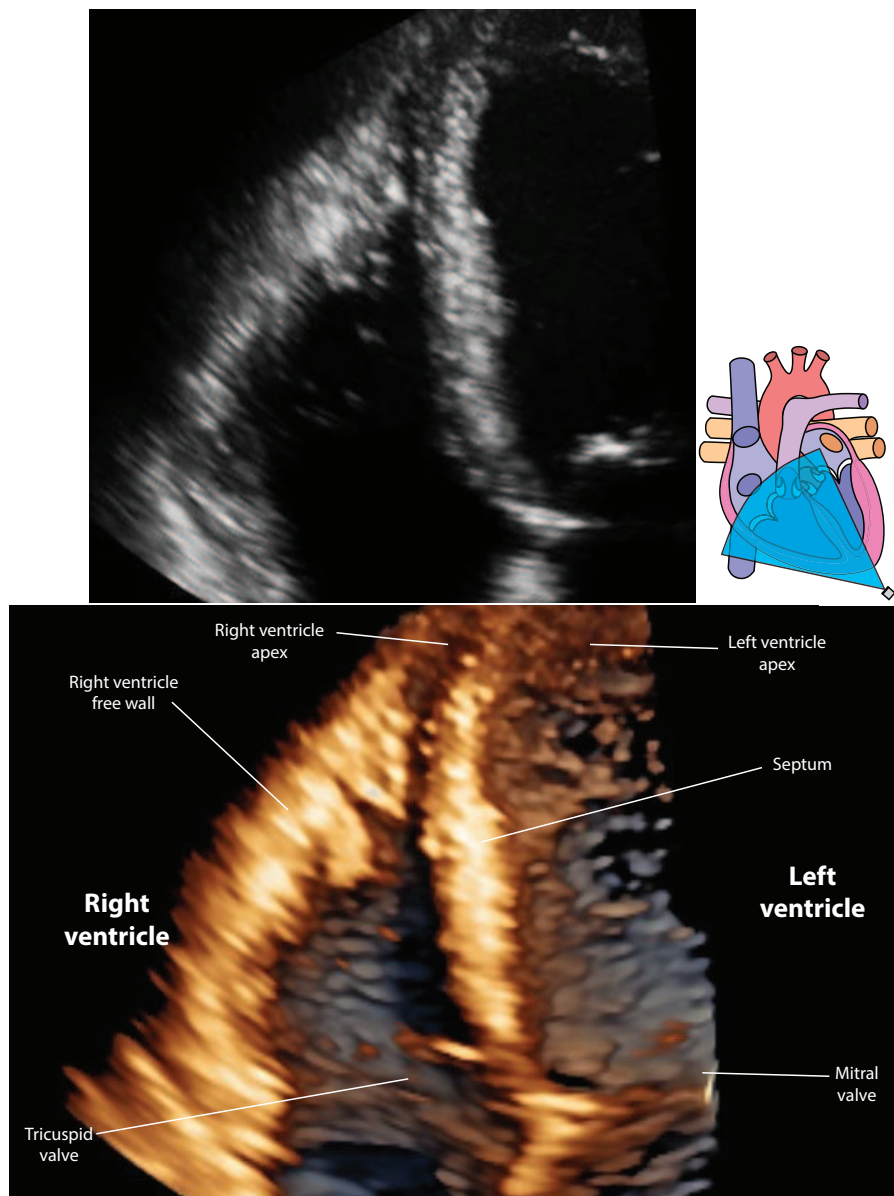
3D ultrasound recording of the right ventricle, taken from an apical position. *Top*: 2D slice through the volumetric data. *Bottom*: 3D rendering of the image.
